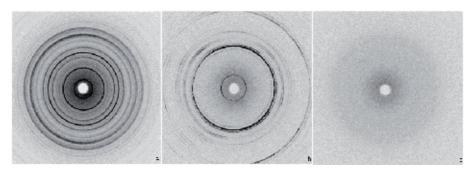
X-ray patterns of Naringin raw material (a), Leucine raw material (b) and NET3-leu5(c).
